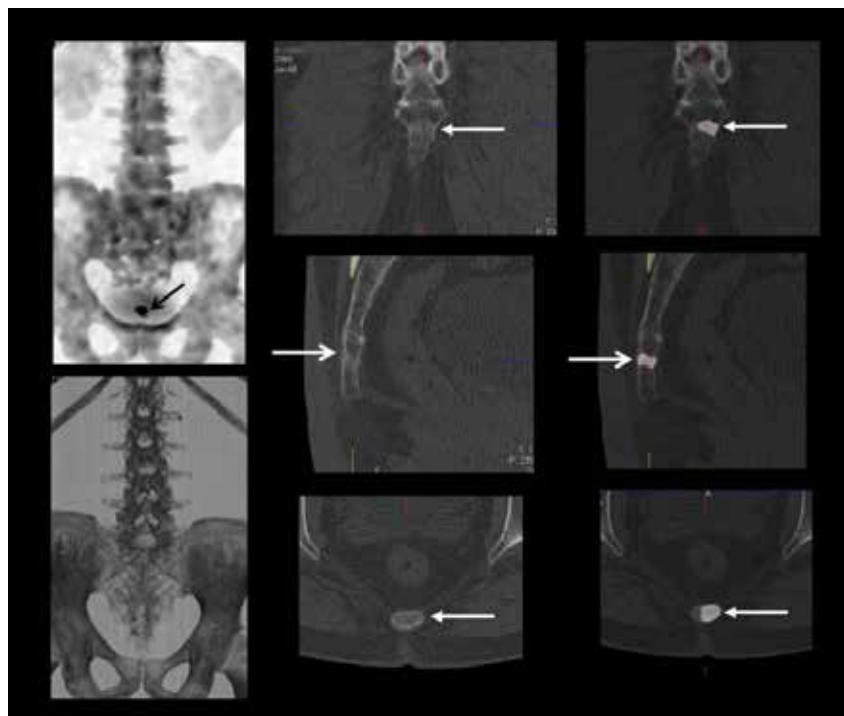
Sagittal reconstruction of thin-slice CT shows oblique fracture line through the mid-coccyx, with mild sclerosis at the fracture line. Fusion of xSPECT Bone and CT shows focal hypermetabolism exactly at the fracture line, with highest uptake intensity posteriorly.
